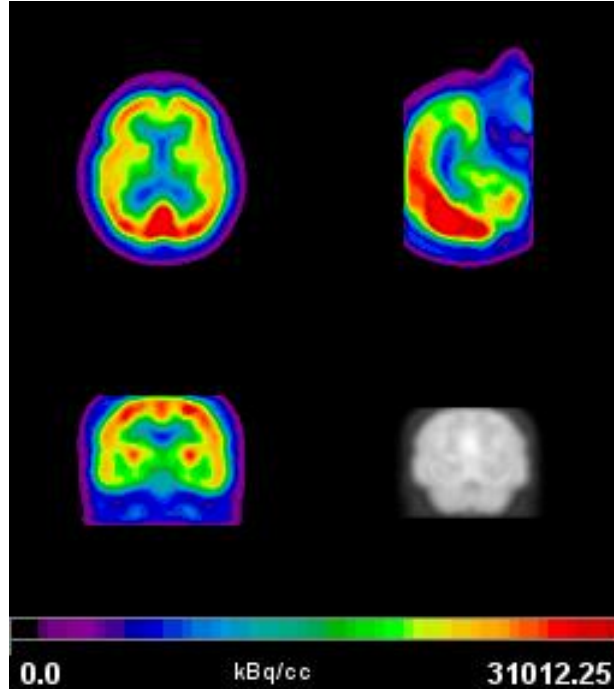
FDG PET: axial, coronal and sagittal orientation.
